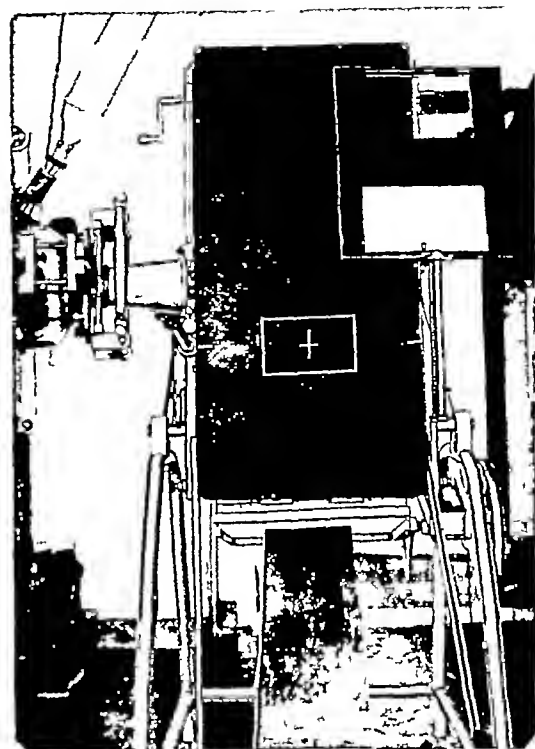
Genito urinary radiographic table in vertical position showing 5 X 8 inch scribed central area. The inclined plane is placed beneath the apparatus. Note the device for shielding one-half of the 8 X 10 inch cassette (placed in the upper right-hand corner of the apparatus) showing protective sheet lead in front and sheet metal back mounted upon a wooden frame having a metal bar at the upper end which facilitates its removal from the grid tray
